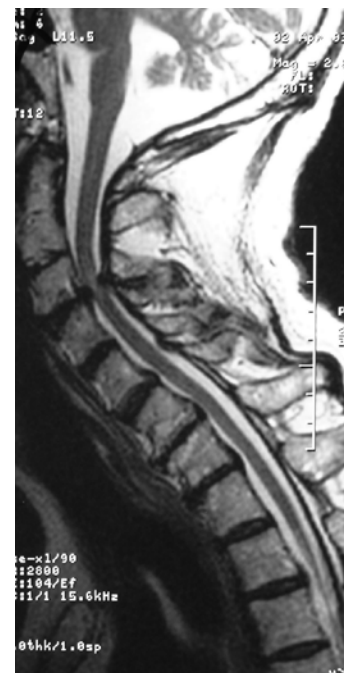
MRI of the spinal cord
